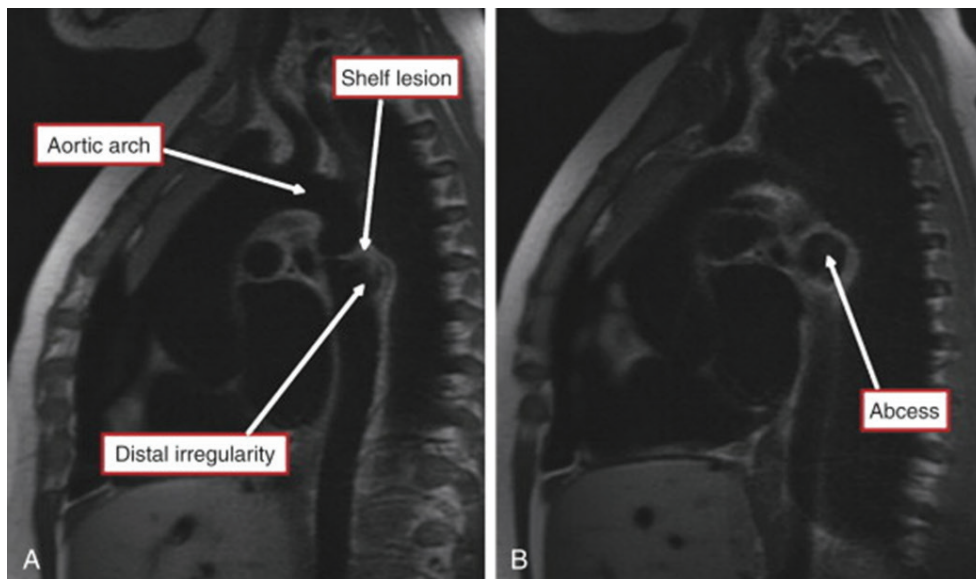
Magnetic resonance imaging of a 7-year-old girl which demonstrates (A) shelf in the aortic arch and (B) abscess of the aortic arch.
